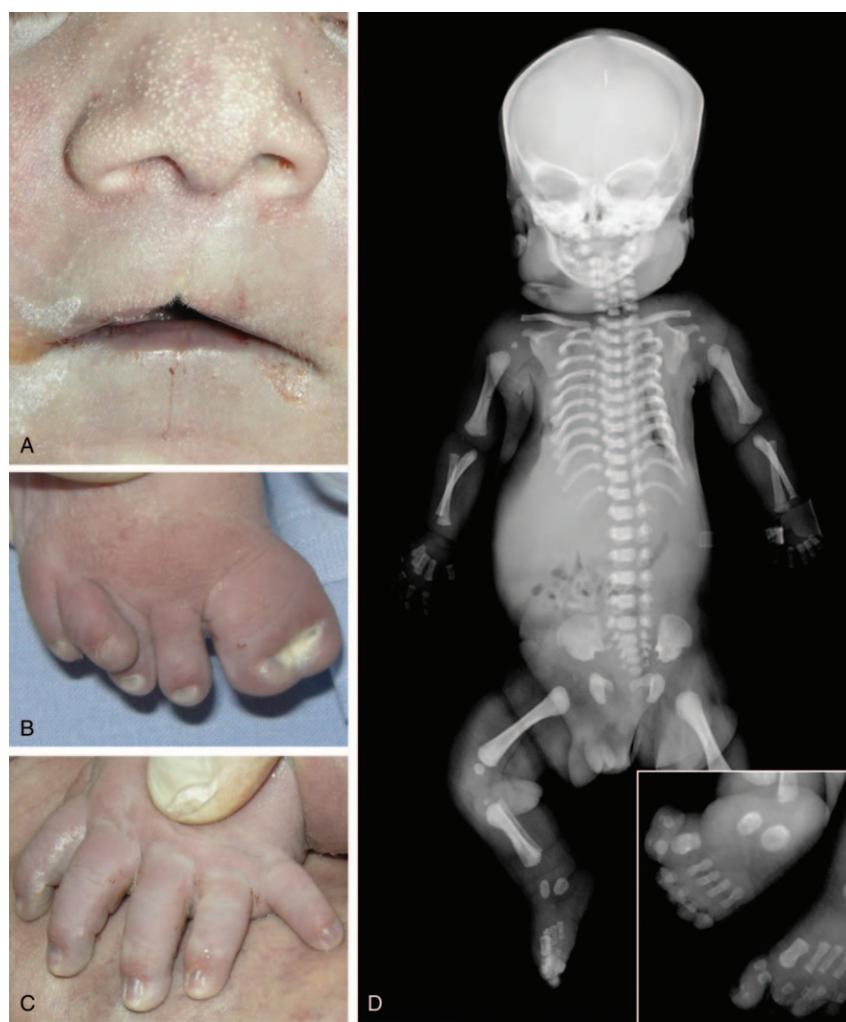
Patient 1 (A) Bulbous nose, multiple nasal milia and midline notch of the upper lip; (B) hallux duplication; (C) postaxial polydactyly of the hand. (D) Total body X-rays showing 11 short ribs and shortened long bones; magnification box revealing duplication of the proximal and distal phalanges of the halluces.
